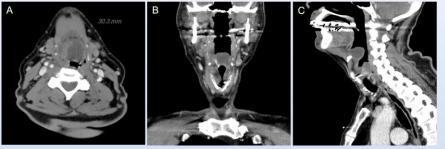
Computed Tomography (CT) image of a 75-year-old male who presented with worsening odynophagia and sore throat. Axial (A), coronal (B), and sagittal (C) plane revealing 3 x 2.4 x 2.2 cm hypodense mass with well-defined margins of epiglottis.
